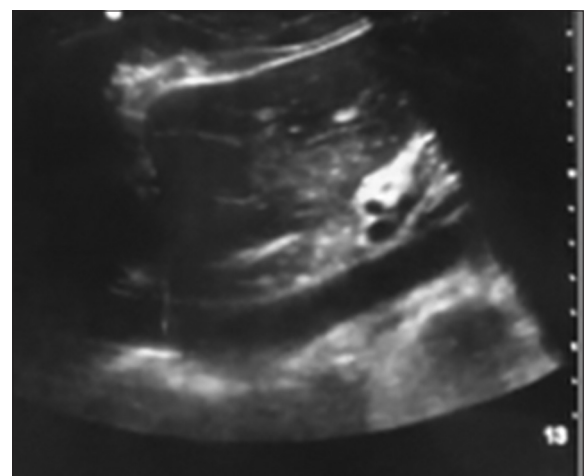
Ultrasound picture showing the inferior vena cava after the removal of the guidewire
